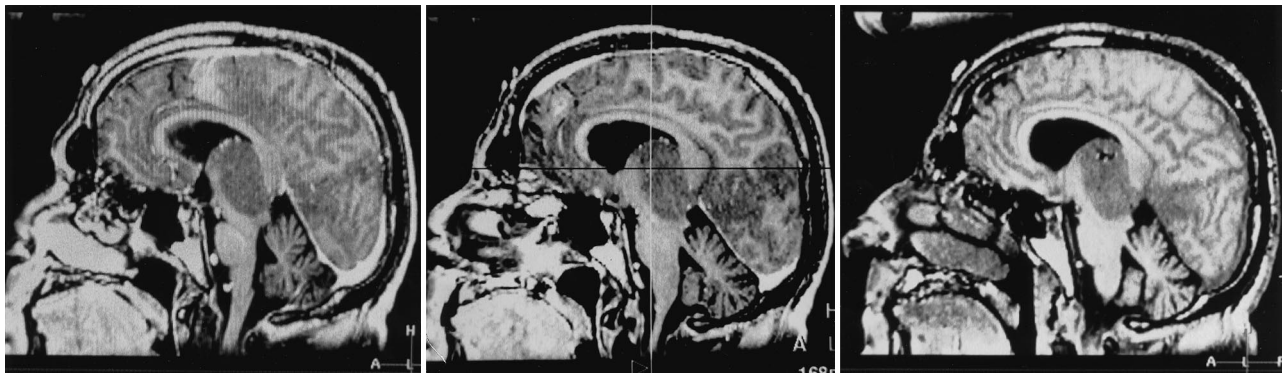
Case 5. Sagittal MR images selected from the series of frameless stereotactic biopsy procedures demonstrating the preoperative appearance of the lesion (*left*), the captured intraoperative target (*center*), and the postoperative appearance of the biopsy site (*right*). Fusion of preoperative and postoperative data sets enabled the *in vivo* error to be calculated.
